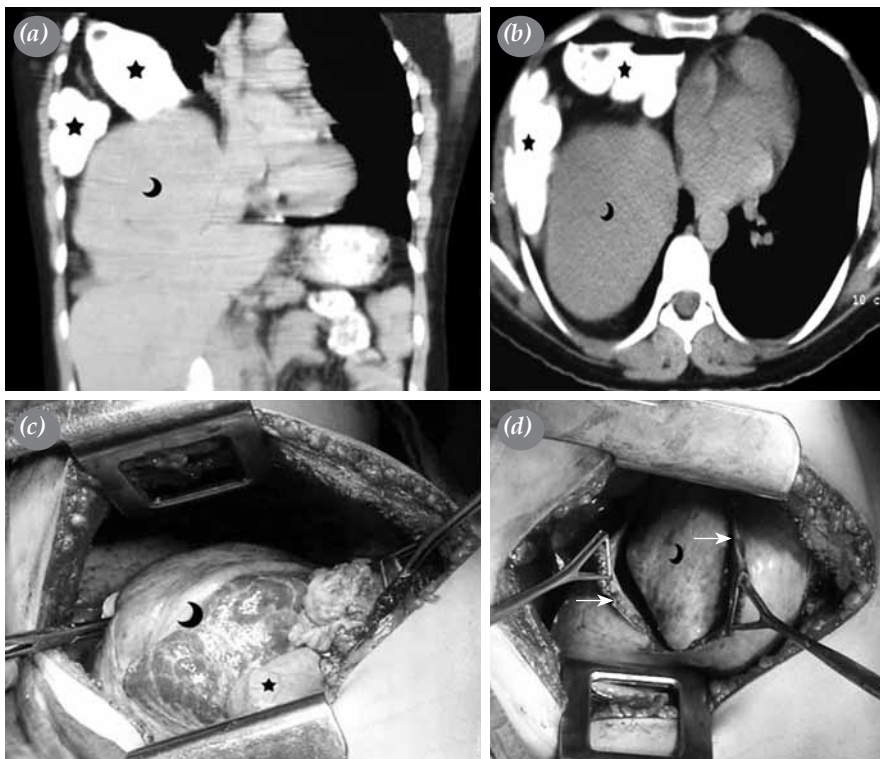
(a, b) Computed tomography images showing the right diaphragmatic rupture in the latent phase along with the liver (crescent), and colon (stars); (c) A preoperative view of the same patient showing the liver (crescent) and colon (stars); (d) An image showing the liver (crescent) and the leaf of the diaphragm (arrows).
